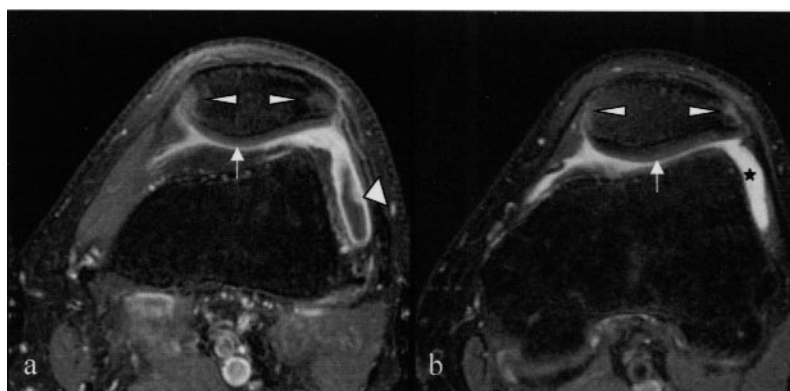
MRI axial examination of the left knee in a 25-year-old patient with ankylosing spondylitis. Synovitis (↗), bone marrow edema (BME) in the enthesal site (↖), and effusion (★) are visible on axial FS T1-weighted post-contrast image (a) and FS T2-weighted image (b). No patellar cartilage lesions were observed (↗).
